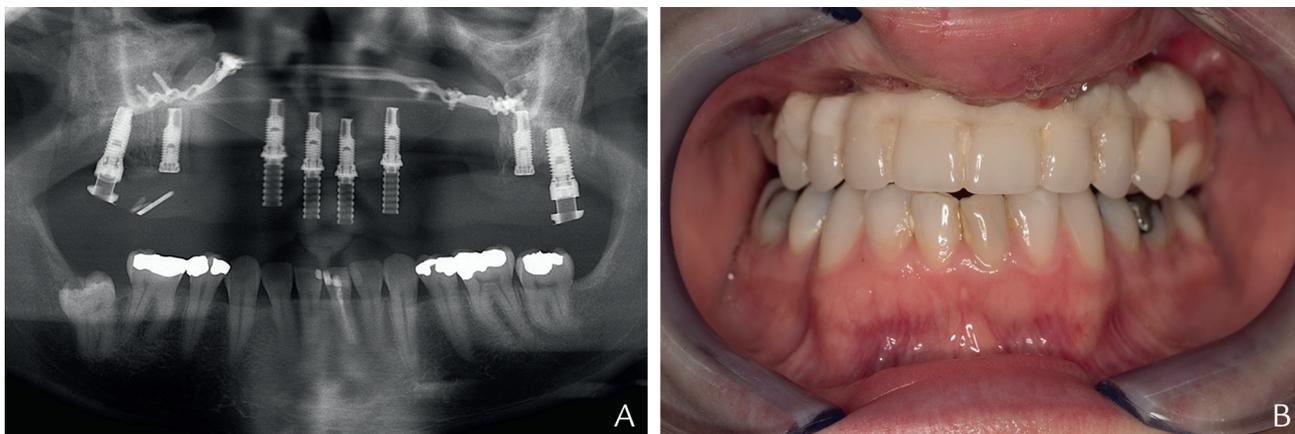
A, Stepwise progression radiograph after additional implant placement. B, Interim prostheses after placement of implants to native maxilla.
